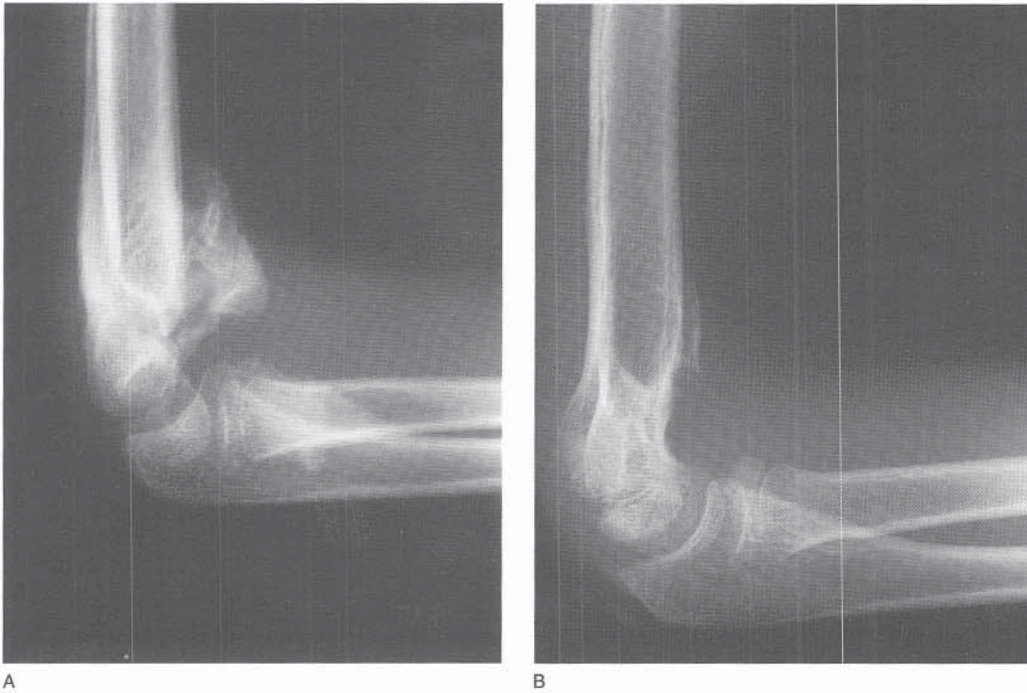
Myositis ossificans following type III supracondylar humeral fracture. A, Lateral radiograph obtained 3 months after injury. Note the significant calcification in the anterior soft tissues. B, Three years after injury, the myositis has resolved without treatment.
